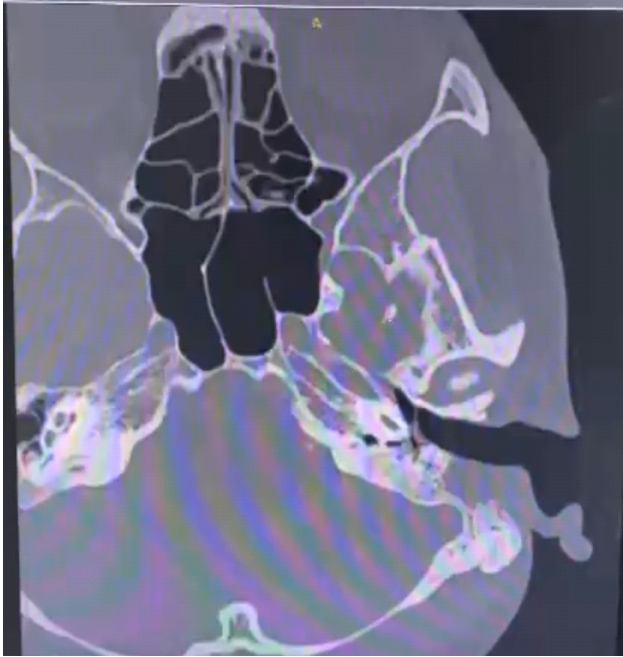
(b): High-resolution computed tomography (HRCT) of temporal bone. Presence of chronic otomastoiditis with post-operative changes and soft tissue densities at the remnant of the left mastoid air cells.
